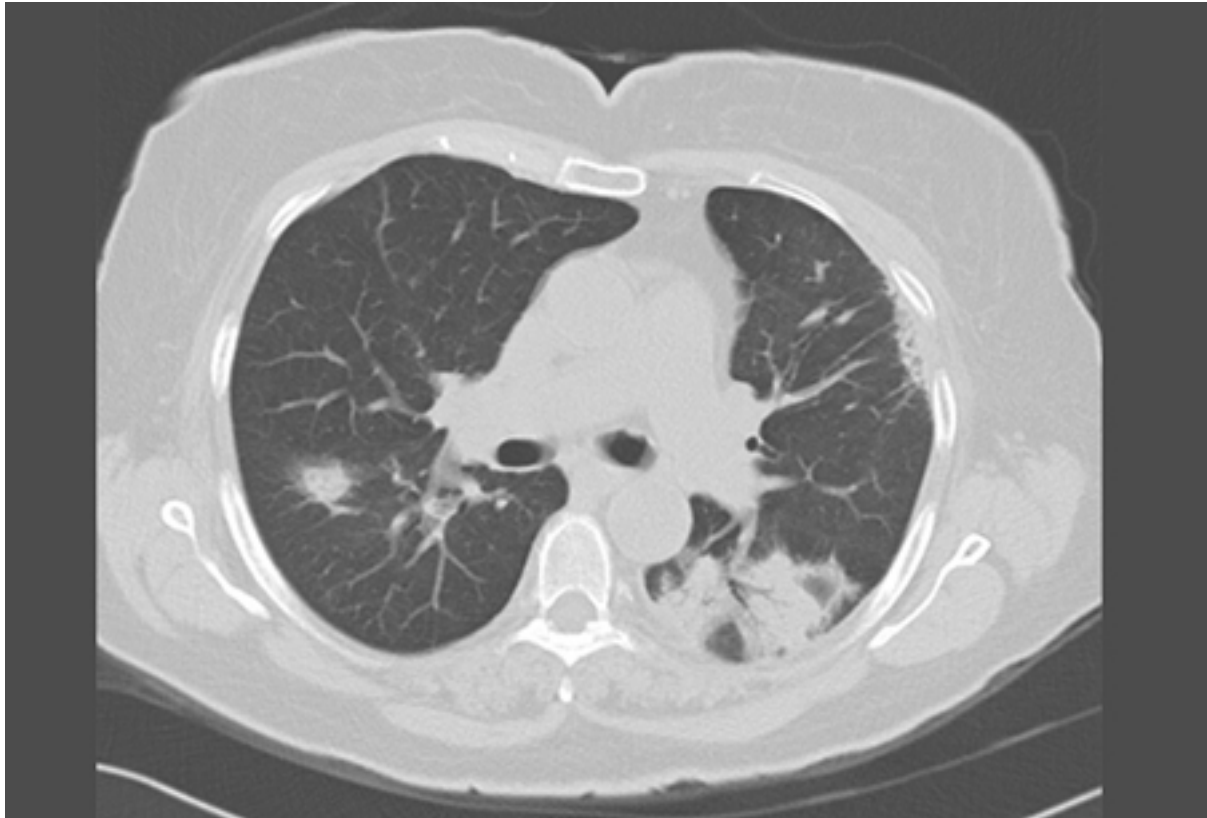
High-resolution chest CT showing bilateral ground glass opacities and a posterior triangular-based infiltrate with an air bronchogram
